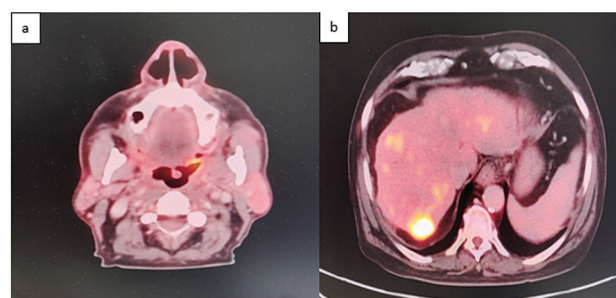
Positron emission tomography-computed tomography (PET-CT) showing focal metabolic uptake in the left tonsillar region (A). Fluorodeoxyglucose (FDG)-avid right lobe liver lesion (B).
